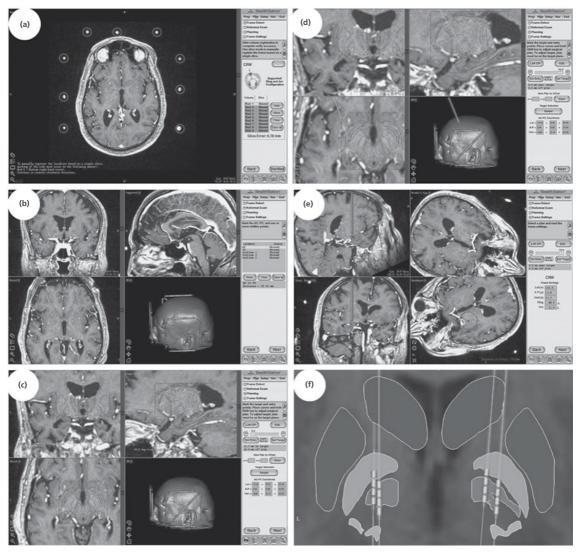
Stereotactic planning of DBS electrodes. Images from the Stealth Framelink software (Medtronic), showing the stages of planning a DBS electrode insertion. (a) The contrast-enhanced MRI is performed after affixing the stereotactic frame base ring (in this case a CRW Stereotactic System, Integra). The locations of the fiducial bars (9 circled points) is noted by the software, to register the brain MRI space to the physical space of the frame allowing transformations of brain targets to the instrument holder. (b) The locations of the anterior commissure (AC) and posterior commissure (PC), and the line connecting them, provide a consistent internal reference for a 3D space in which common functional stereotactic targets such as the basal ganglia can be targeted. Here AC and PC are noted in the software for targeting with respect to the AC–PC line (synonymous with a so-called Talairach space). The 3D reconstruction of the fiducial localizer box is seen in the bottom right corner. (c) Most software programs allow a digital version of the classic Schaltenbrand and Wahren (or other) atlas to be co-registered to the patient's MRI scan via AC/PC coordinates, to aid in so-called indirect targeting. Here the target in the globus pallidus (red dot) has been selected based on its relationship to the AC–PC line and the atlas. (d) The entry point is chosen to provide a rational trajectory for the DBS lead (i.e. here proceeding rostrally through the globus
